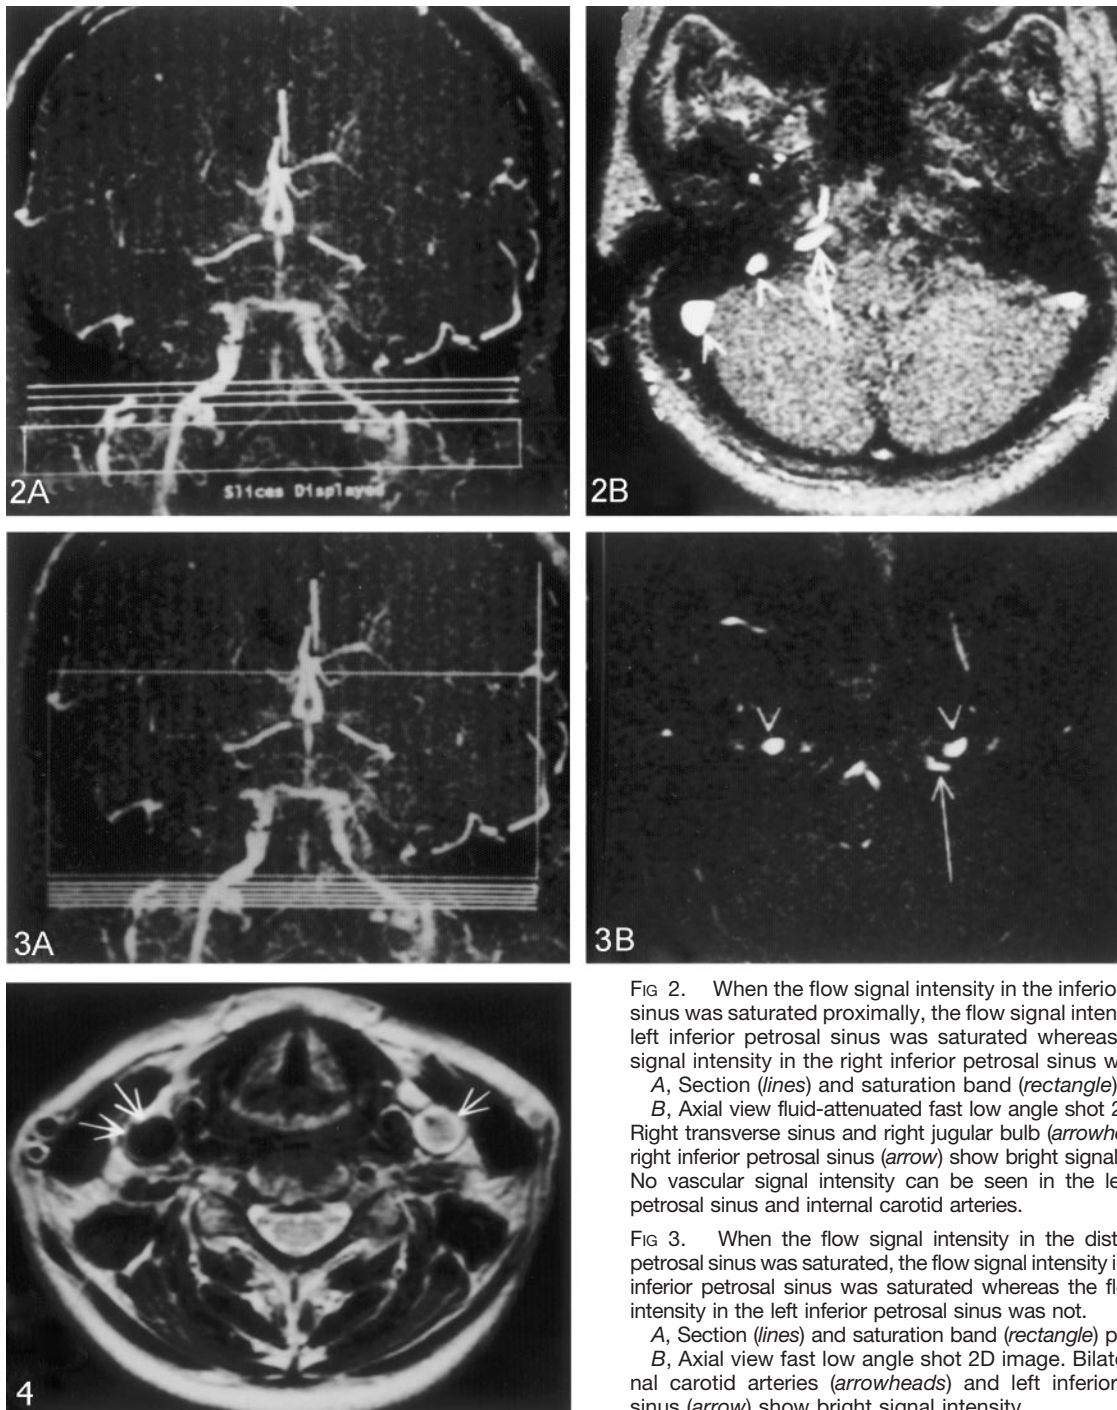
Axial T2-weighted MR image shows normal flow void in the right internal jugular vein (arrows), whereas flow-related enhancement can be seen in the left internal jugular (arrow) vein due to sluggish flow.
